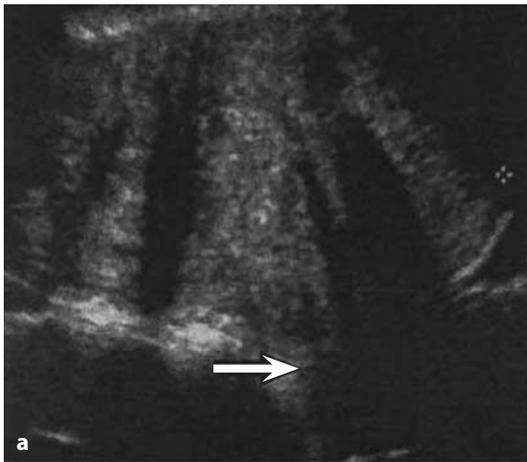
Acute torsion of a uterine leiomyoma. A 30-year-old woman with torsion of a pedunculated subserosal leiomyoma. a Suprapubic US examination in the sagittal plane shows a large (13 cm in diameter), echogenic, heterogeneous mass that compresses the bladder. The uterus is displaced posteriorly (*arrow*). Shadows inside the mass are due to acoustic reflections. b Unenhanced CT scan shows a large, slightly heterogeneous, abdominopelvic mass (mean value 45 HU). Some linear parts have a higher value of 55 HU. c Contrast-enhanced CT scan shows intense rim enhancement localized against uptake of contrast medium inside tortuous vessels between the upper anterior part of the corpus uteri and the mass (*large arrow*). There is no enhancement inside the mass. The left ovary is normal and far from the mass (*arrowhead*). Note fluid inside the cul-de-sac (*small arrow*). d Contrast-enhanced CT scan at a level inferior to that depicted in (c) shows thin rim enhancement that is more intense in contact with persistent uptake of contrast medium against the anterior part of the uterus (*arrow*). No enhancement inside the mass was recorded. The endometrial cavity is normally enlarged during the second part of the menstrual cycle. The right ovary is normal (*arrowhead*). (Reproduced with permission from [224])
